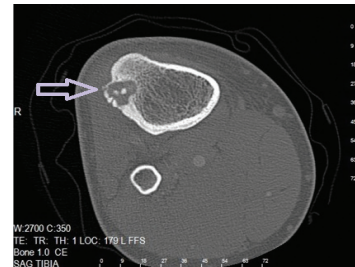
Preoperative CT scan of the tibia of the patient; arrow shows double nidus.
